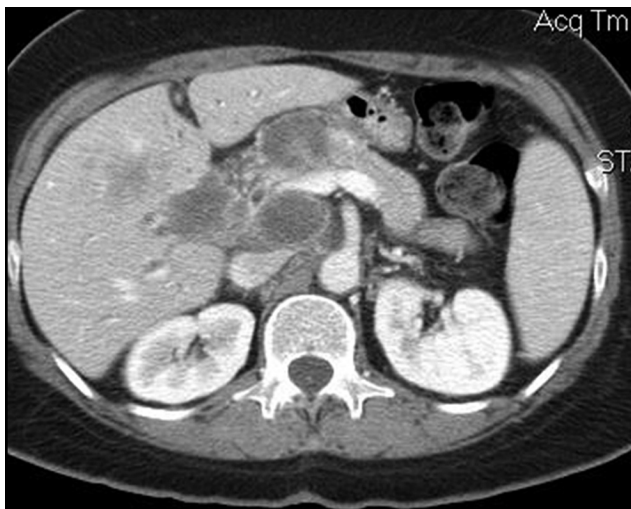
Computed tomography showing 7 × 5 cm gallbladder mass infiltrating the liver.
